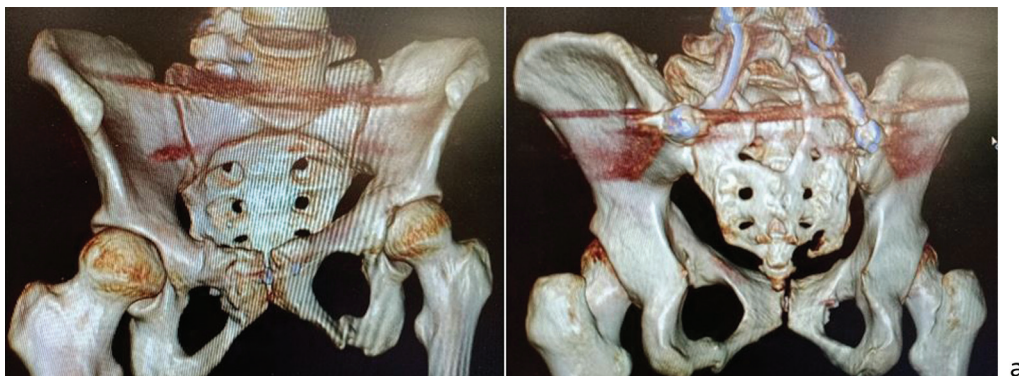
Computed tomography scans of the pelvis at 12 months of surgery showing (a) 3D reconstruction
